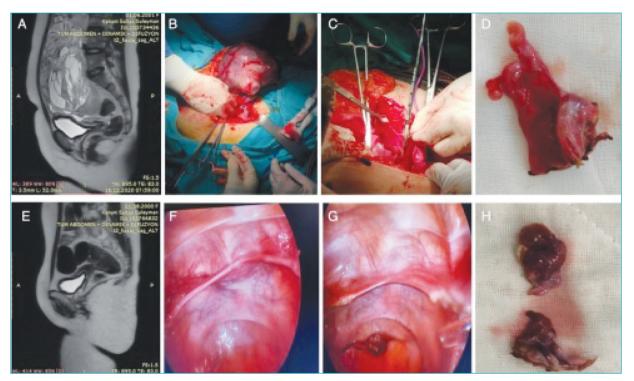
CE-MRI findings and laparotomic observation of adnexal mass and uterus of the index case, CE-MRI findings and laparoscopic observation with gonadectomy of the elder sister. A) CE-MRI at the T2-A series showing infantile uterus and abdominal pelvic mass (17×18×19 cm) which contain calcifications and minimal papillary projections of the index case; B) Torsioned massive 20 cm ovarian mass with cystic and hemorrhagic areas originated from the left adnexa of the index case; C) Hypoplastic and bicornuate shaped uterus of the index case; D) Streak and infantile right ovary of the index case; E) CE-MRI at the T2-A series showing hypoplastic uterus without any adnexal mass of the elder sister; F) Laparoscopic image of the hypoplastic uterus of the elder sister; G) Laparoscopic image of gonadectomy of the elder sister; H) Bilateral streak and infantile gonadectomy and salpingectomy of the elder sister. CE-MRI: Contrast-enhanced magnetic resonance imaging.
